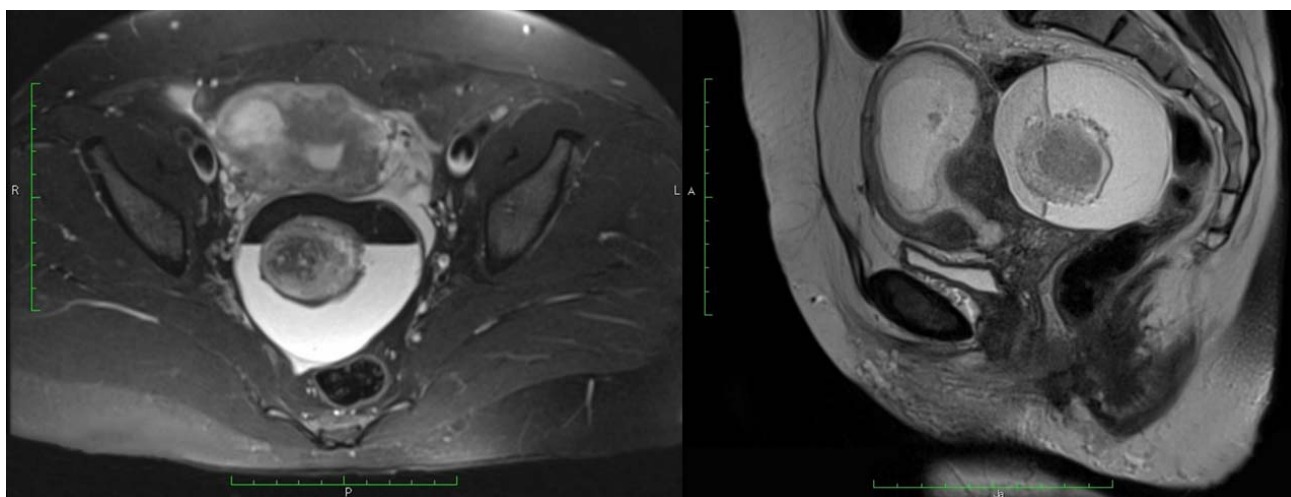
Axial and sagittal MRI showing left ovarian fluid cyst with a two-phase liquid-fat system. Centrally inside the cyst, a spherical lesion with heterogeneous signal intensity and a diameter of about 40 mm (most likely a thrombus) is identified.
